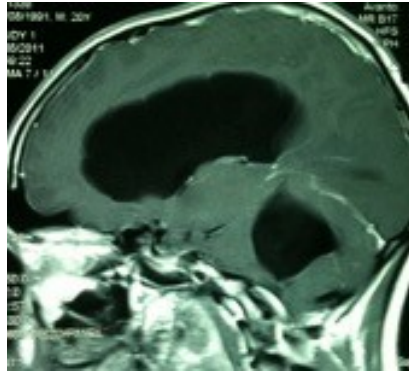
MRI shows double compartmental HCP. Source: Figure by authors.
